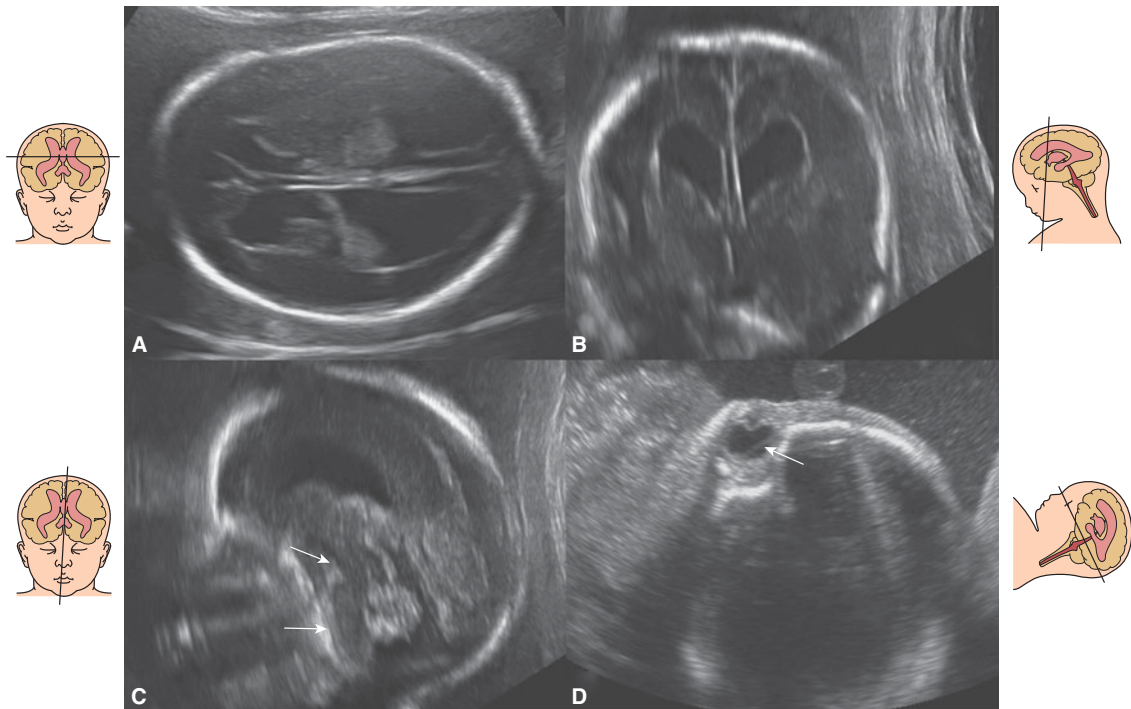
Neurosonographic transabdominal examination at 21 postmenstrual weeks consistent with recurrent WWS. In the previous pregnancy, a fetus with suspected WWS was diagnosed at 26 weeks of pregnancy. (A) Axial transventricular plane shows mild ventricular dilation (12.6 mm). (B) Coronal plane through the frontal horns shows dilation. (C) Median plane shows the abnormal shape of the kinked brainstem and lack of the anterior protuberance of the pons (arrows). (D) The presence of retinal detachment is confirmatory of the diagnosis (arrow).
